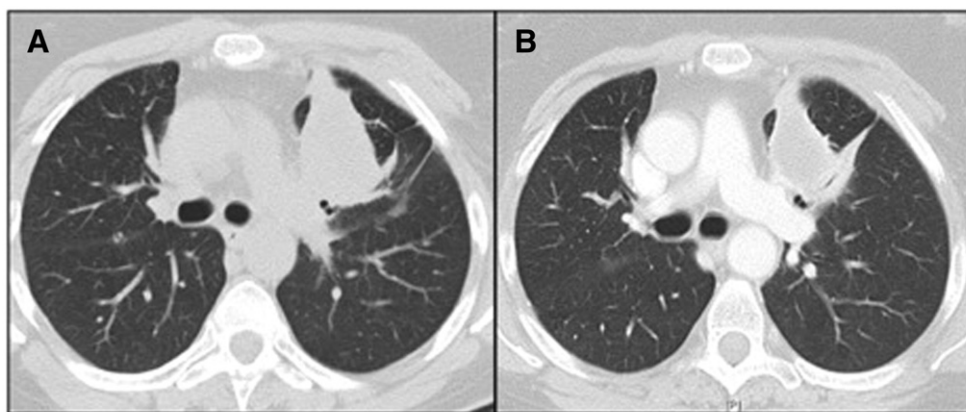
Chest computed tomography showing the tumor response to treatment with FGFR inhibitor. Panel A: baseline tumor measuring 61 mm. Panel B: tumor after 4 cycles measuring 54 mm.
